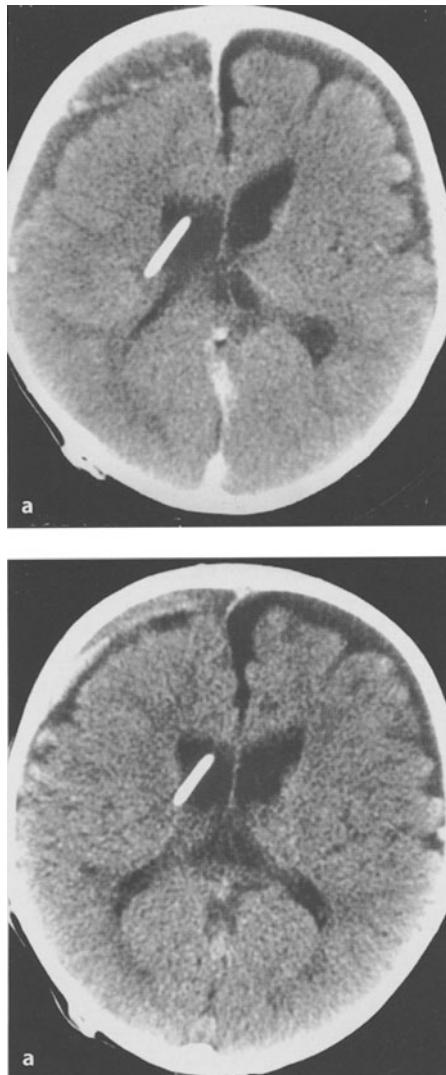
Subdural collection after ventriculoperitoneal shunting. Spontaneous resolution without surgical intervention. a CT scan of an 18-month-old child, shunted for hydrocephalus. A month after the operation he presented with a focal seizure. There was a right frontal subdural haematoma. The underlying cerebral hemisphere was compressed and distorted. b Following a 2-month period of observation without surgical intervention, repeat CT scan showed partial resolution of the subdural collection. The mass effect on the underlying cerebral hemisphere had resolved and the brain had a more normal disposition
